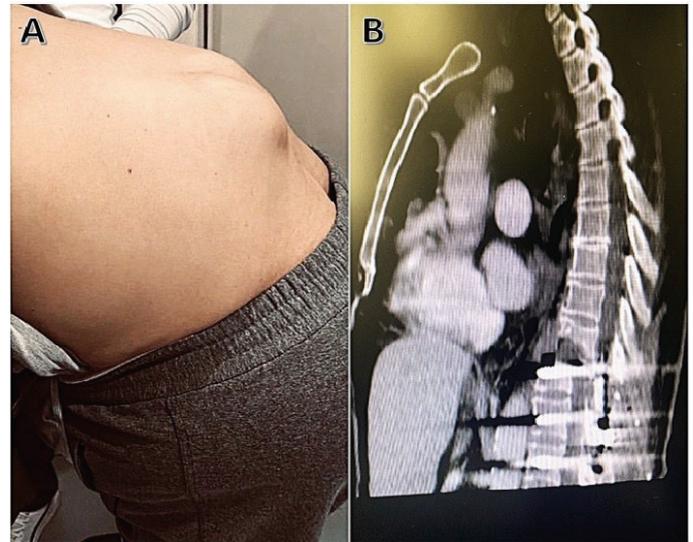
Picture of Physical (A) and CT Appearance of Fracture (B).
